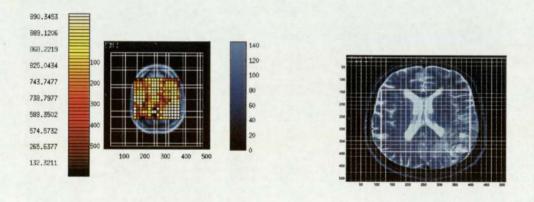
Gadolinium-enhanced MRI scan for a glioblastoma patient with and without NeuroScale distances mapped on top (Euclidean distance).
